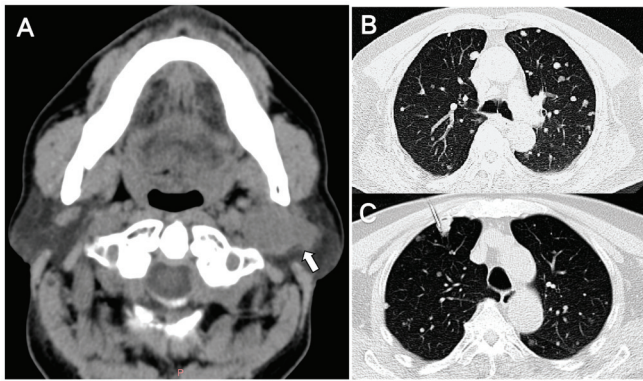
CT findings of epithelial-myoepithelial carcinoma in the parotid gland and pulmonary metastasis. (A) CT of the parotid gland indicated the presence of a space-occupying lesion in the parotid region. (B) Axial chest CT reveals the presence of multiple randomly distributed nodules in both lungs. (C) Precise fine-needle aspiration biopsy completed under positron emission tomography-CT guidance. CT, computed tomography.
